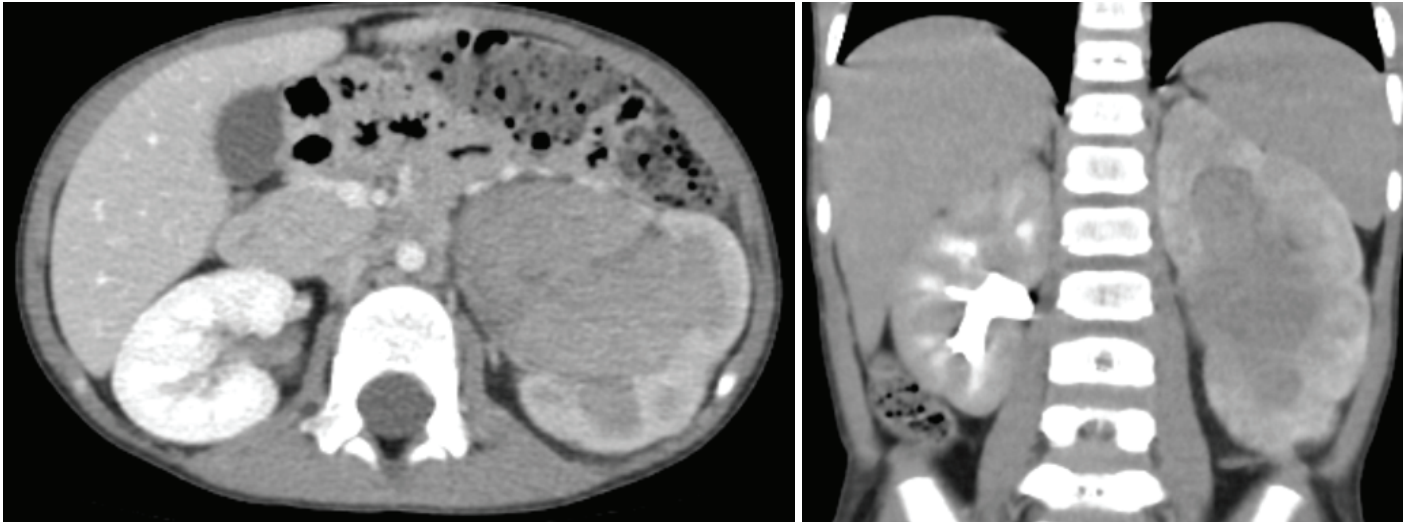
Axial (nephrogram phase) and coronal (pyelography phase) CT images.
